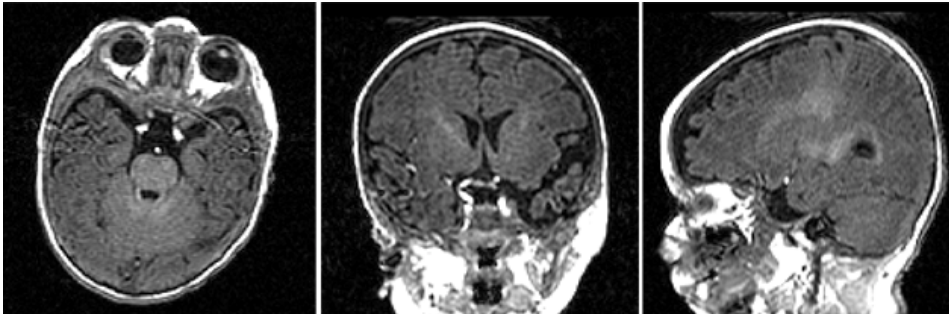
MRI data of normally developed skulls
